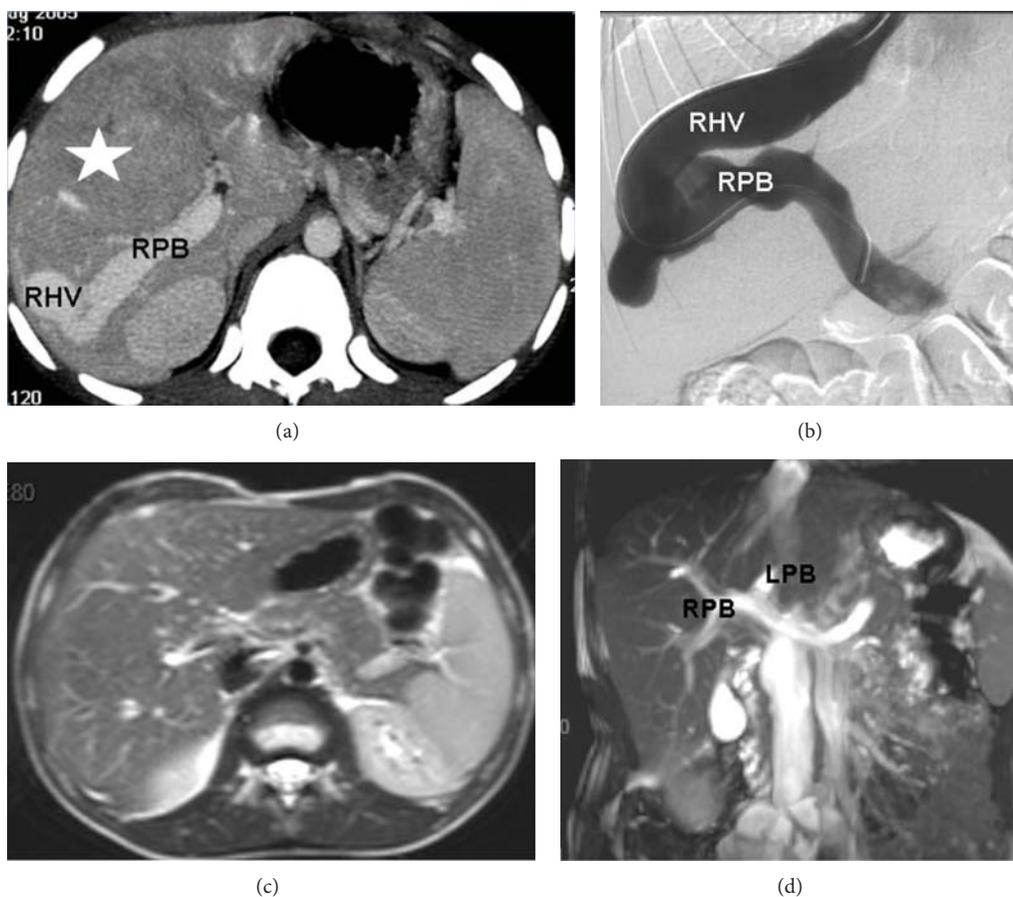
Six-year-old boy with a congenital portohepatic shunt complicated by a biopsy-proven FNH measuring 7 cm diameter (white star). (a) Contrast-enhanced CT scan at diagnosis shows an abnormal and large communication between the right portal branch (RPB) and the right hepatic vein (RHV). (b) Phlebography with opacification of the shunt between the RPB and the RHV. Closure of the shunt was performed by interventional radiology. (c) MRI performed seven years later shows the disappearance of FNH on the T2-weighted images. No enhancement was present at the arterial phase after gadolinium injection (not shown). (d) Note the normal aspect of the portal bifurcation (RPB and left portal branch (LPB)) on coronal MIP reconstruction of the T2-balanced sequence.
